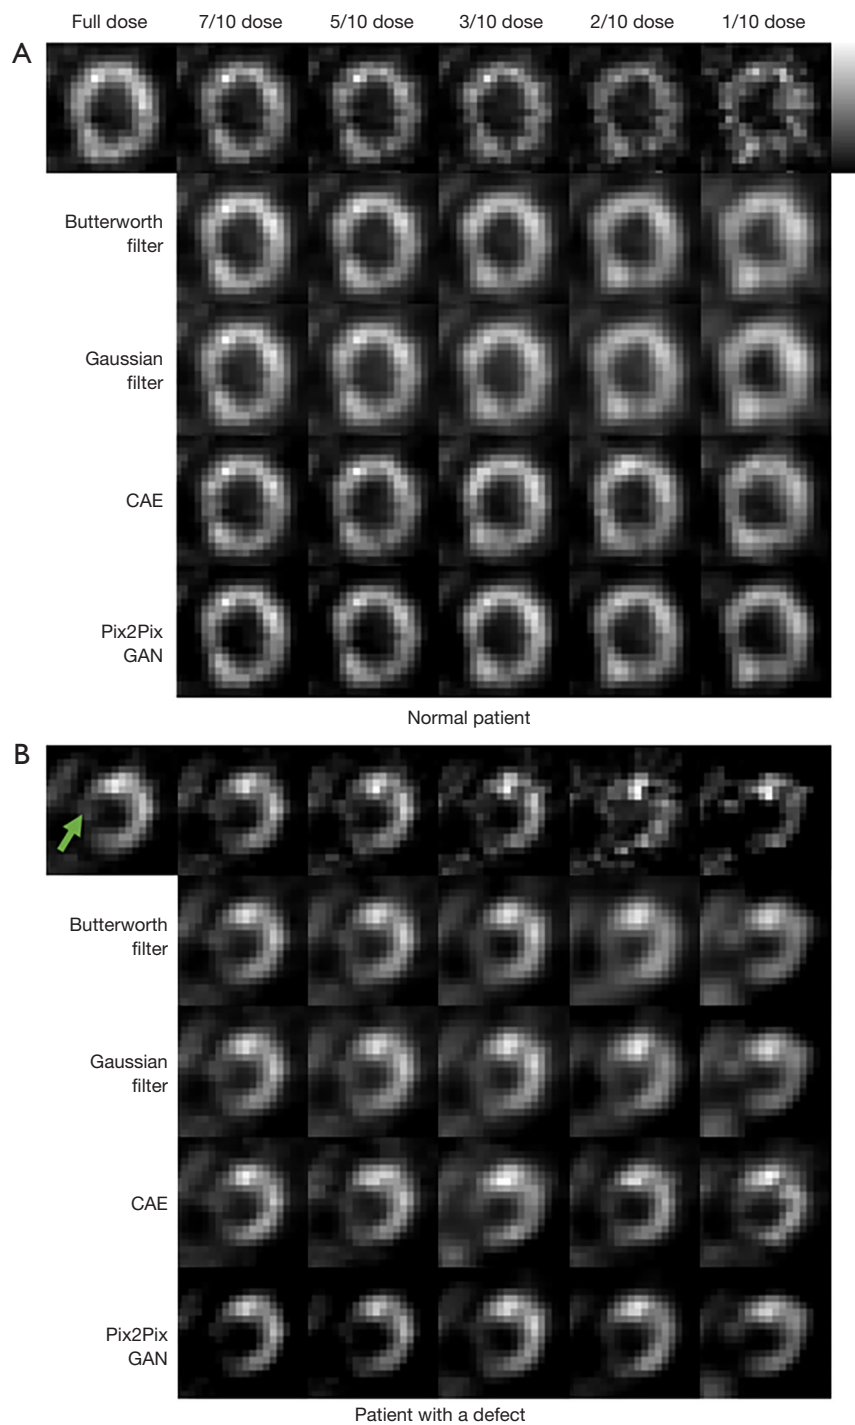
Clinical MP SPECT images with various noise levels of (A) a sample normal patient (male, age =49 years, BMI =25.5 kg/m²) and (B) a sample patient (male, age =76 years, BMI =19.2 kg/m²) with a known cardiac defect (green arrow) processed under different denoising methods. CAE, convolutional auto encoder; GAN, generative adversarial network; MP, myocardial perfusion; BMI, body mass index.
